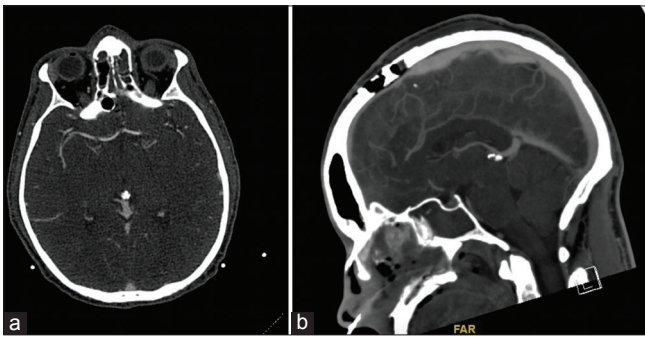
Vascular imaging. (a) Preoperative computed tomography (CT) angiogram showing no intracranial vascular injury, and (b) a postoperative CT venogram showing normal filling of the superior sagittal sinus underneath the craniotomy site. A computed tomography angiogram done in a postoperative setting (not shown here) was also negative for vascular injury.
